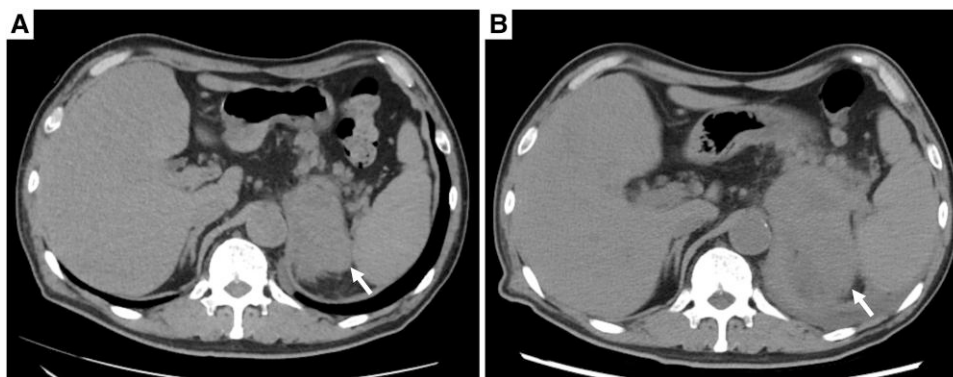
(A) Abdominal CT scan obtained during the initial examination. Left adrenal mass: 75 mm (arrow). Unenhanced attenuation of 35 HUs. (B) Abdominal CT scan obtained postadmission. The left adrenal mass was enlarged to 105 mm (arrow). Unenhanced attenuation of 40 HUs.
